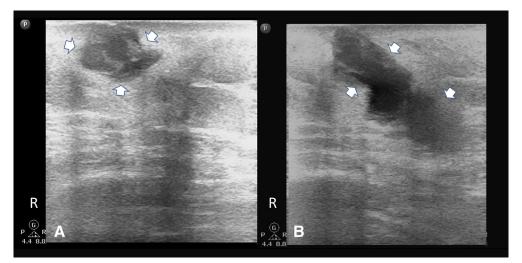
(A) Point-of-care ultrasound of the right chest wall with a linear probe demonstrating in short axis a subcutaneous hypoechoic heterogenic round structure (arrowheads) suspected for a superficial abscess. (B) A longitudinal view of the structure which is described in (A), demonstrating a continuous tract/fistula from the skin (arrowheads) towards the pleura.
